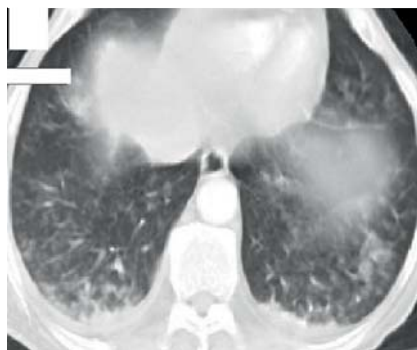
Thoracic computed tomography (CT) scan showing bilateral perihilar infiltration, and ground-glass opacities and areas of consolidation in the middle right and left lobe.
